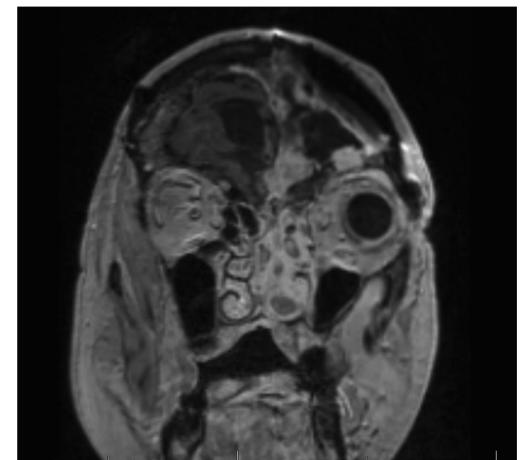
Pre-operative images. A) Sagittal T1 MRI Brain post-contrast. Left-sided meningiomas. B) Coronal T1 MRI Brain post-contrast. Left-sided meningiomas
